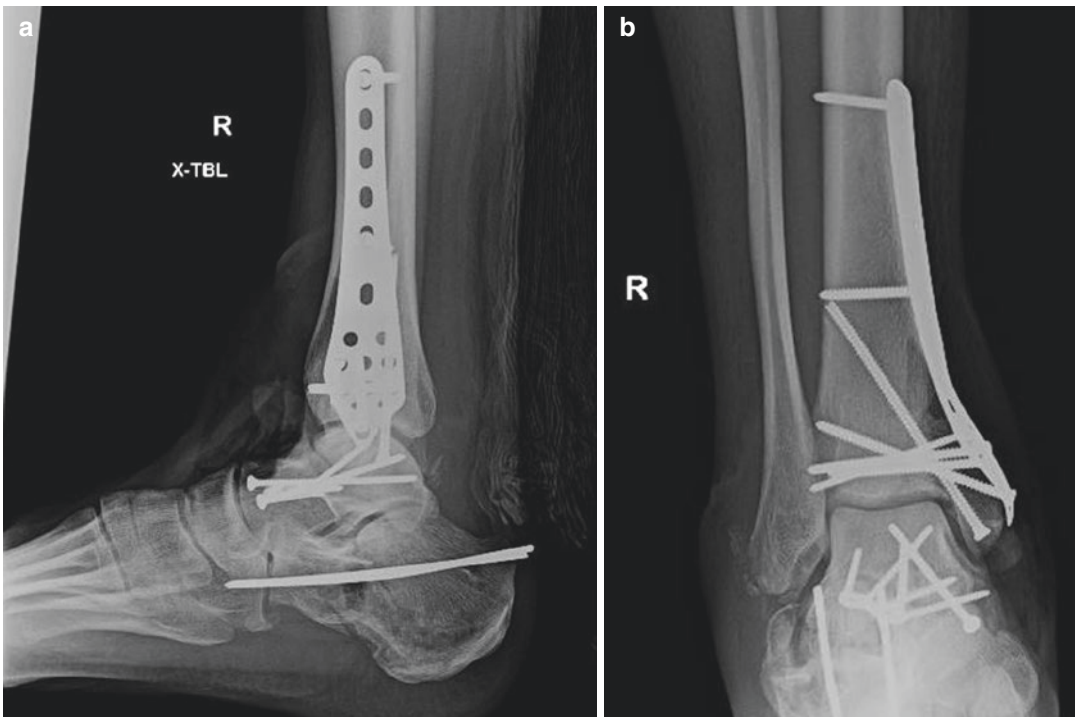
A lateral (a) and AP (b) X-ray demonstrates staged fixation in the injuries seen in Fig. 22.6a,b. The pilon and talar neck fractures were treated with open
